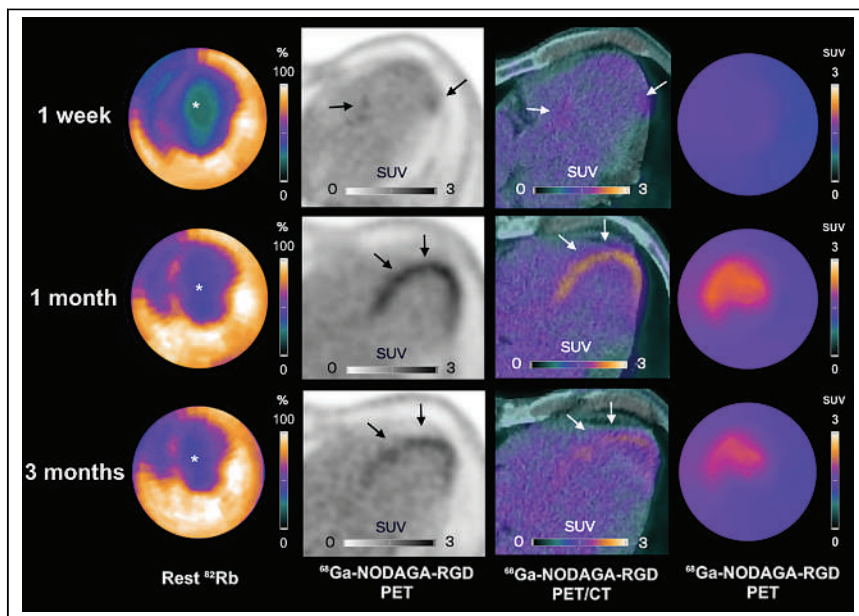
Participant example with increase in $\alpha_v\beta_3$ integrin expression levels (arrows) throughout follow-up within infarcted myocardium (asterisks). Shown are rest ^{82}Rb , ^{68}Ga -NODAGA-RGD PET, and ^{68}Ga -NODAGA-RGD PET/CT images at 1 wk (first row), 1 mo (second row), and 3 mo (third row) after STEMI. ^{68}Ga -NODAGA-RGD uptake started in border zone at 1 mo and subsequently extended into necrotic infarct core at both 1 and 3 mo.
